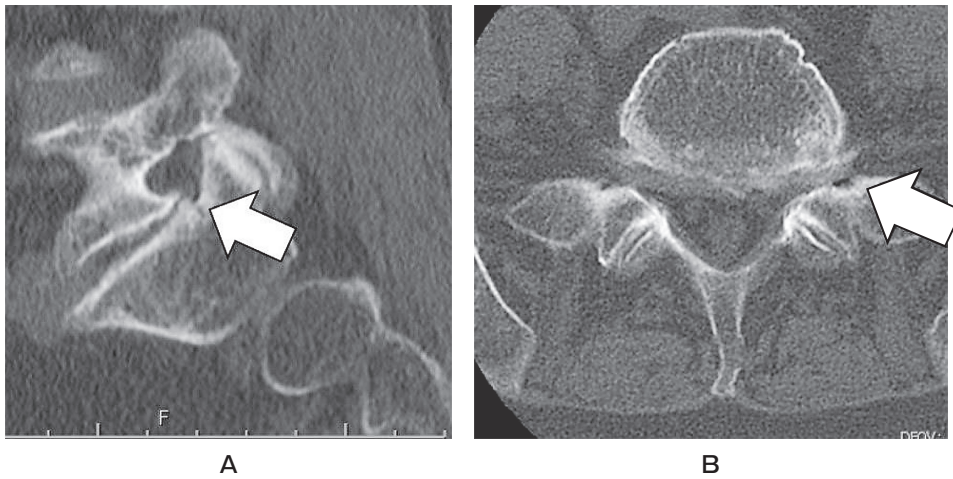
A, A preoperative computed tomography (CT) scan sagittal section shows osteophytes at the L5-S1 foramen on the left side (white arrow); B, A preoperative CT scan axial section demonstrates osteophytes at the L5-S1 foramen on the left side (white arrow).
